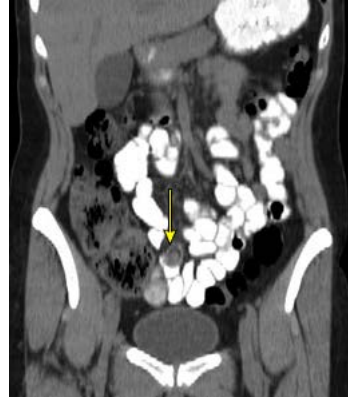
Incidental Meckel's diverticulum on CT scan
